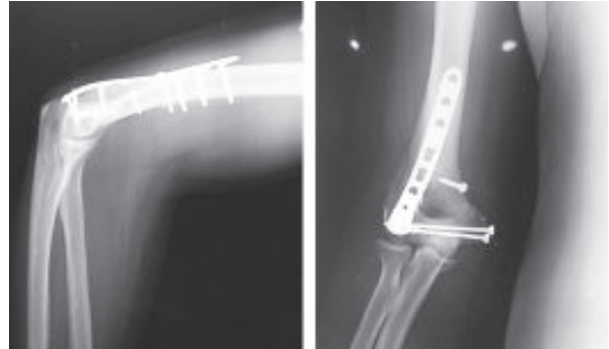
Post- operative x-ray of elbow joint at final follow up (at 6 months)
